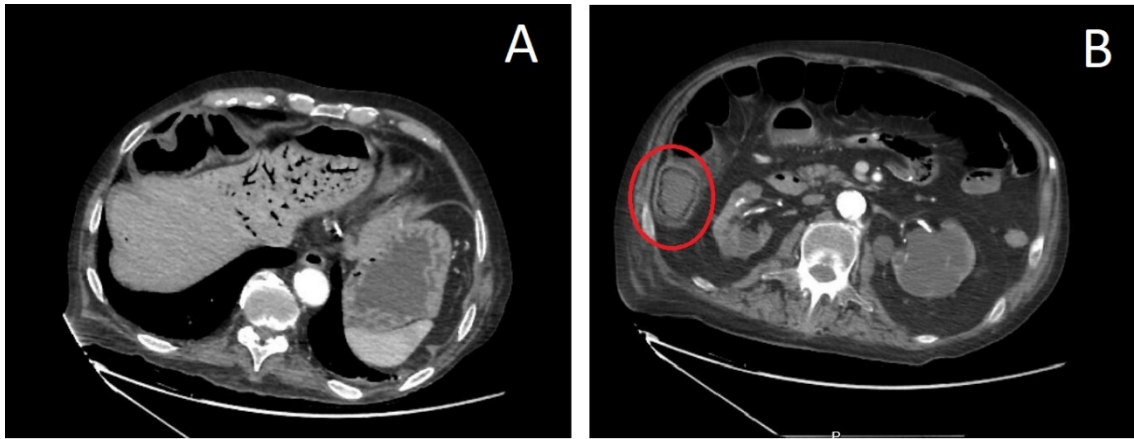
A. CT image of the portal pneumatosis. B. Segment of the ileum (red circle) with signs of intestinal pneumatosis.
